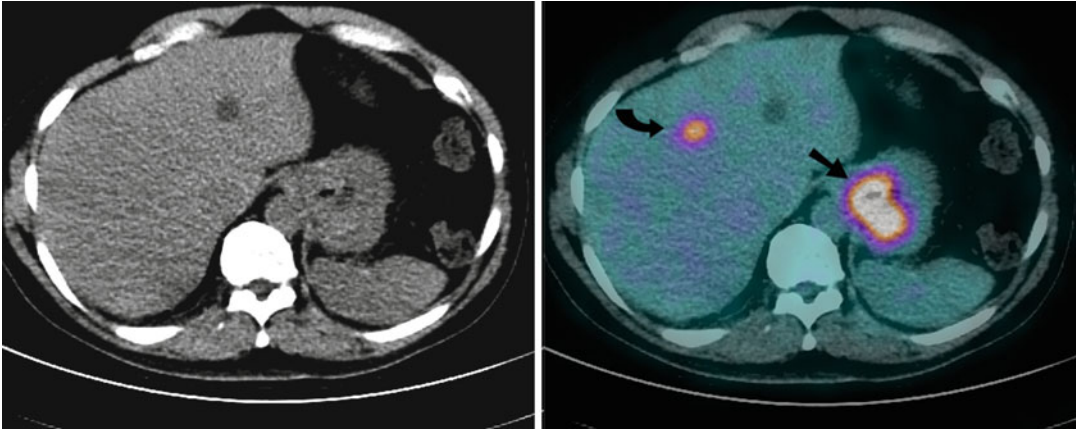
A 67-year-old man with newly diagnosed functioning poorly differentiated gastric adenocarcinoma who underwent preoperative FDG PET-CT scan for staging. Axial CT (*Left*) and combined FDG PET-CT (*Right*) images demonstrated intense focal uptake at the site of the primary (*arrow*), within a perigastric lymph node (not shown) and in segment IV of the liver (*curved arrow*). An incidental hepatic cyst with no increased FDG uptake was noted medial to this lesion. A diagnostic contrast-enhanced CT scan did not demonstrate any significant
